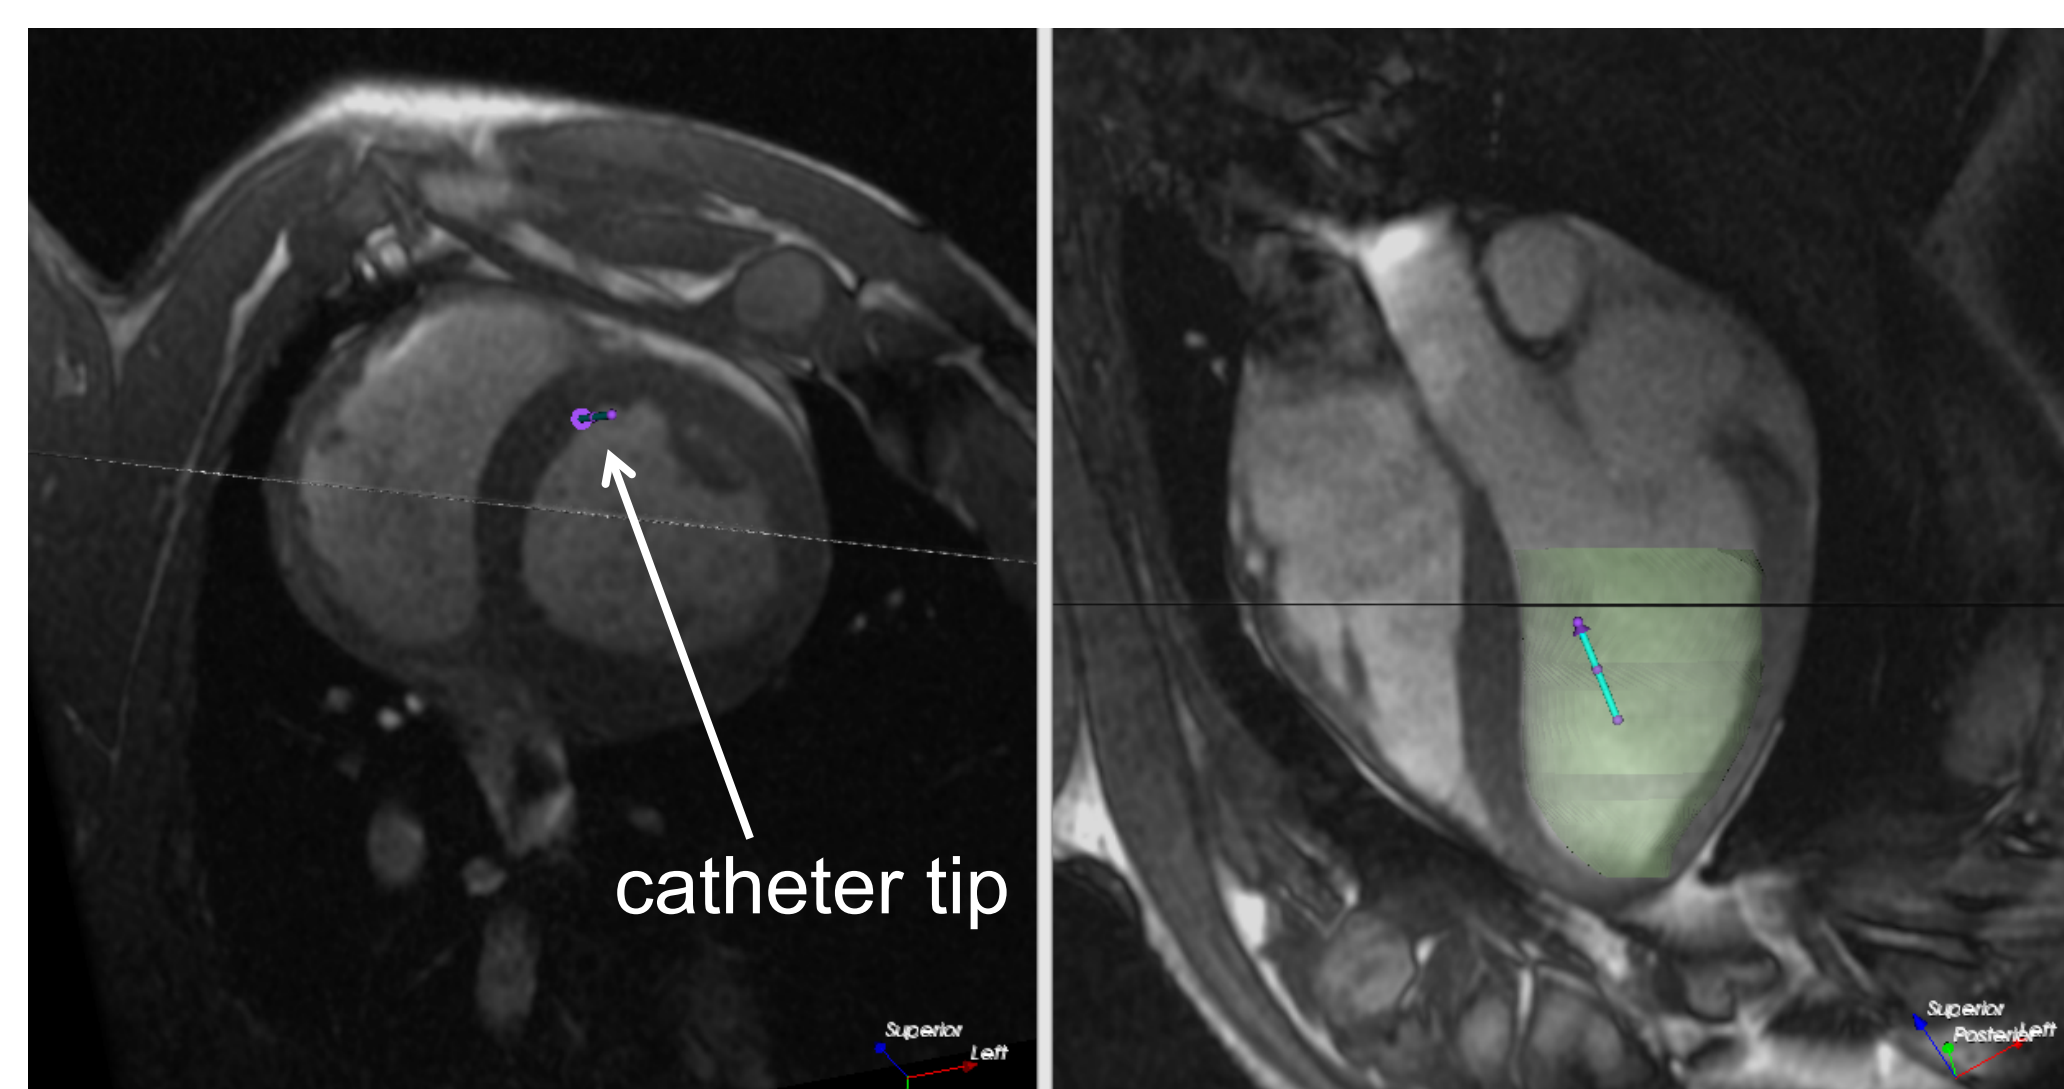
Real-time MR-guided catheter navigation, displayed using Vurtigo. Short-axis and long-axis roadmap MR images are shown on left and right respectively.
